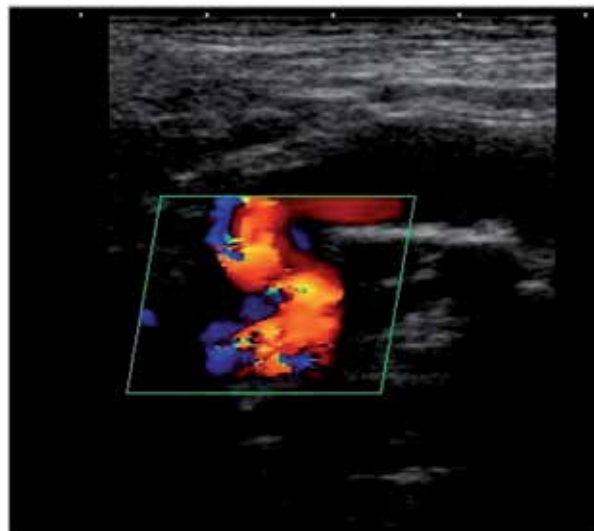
A double angled internal carotid artery showing a S shaped configuration (image corresponding to color Doppler ultrasound)
